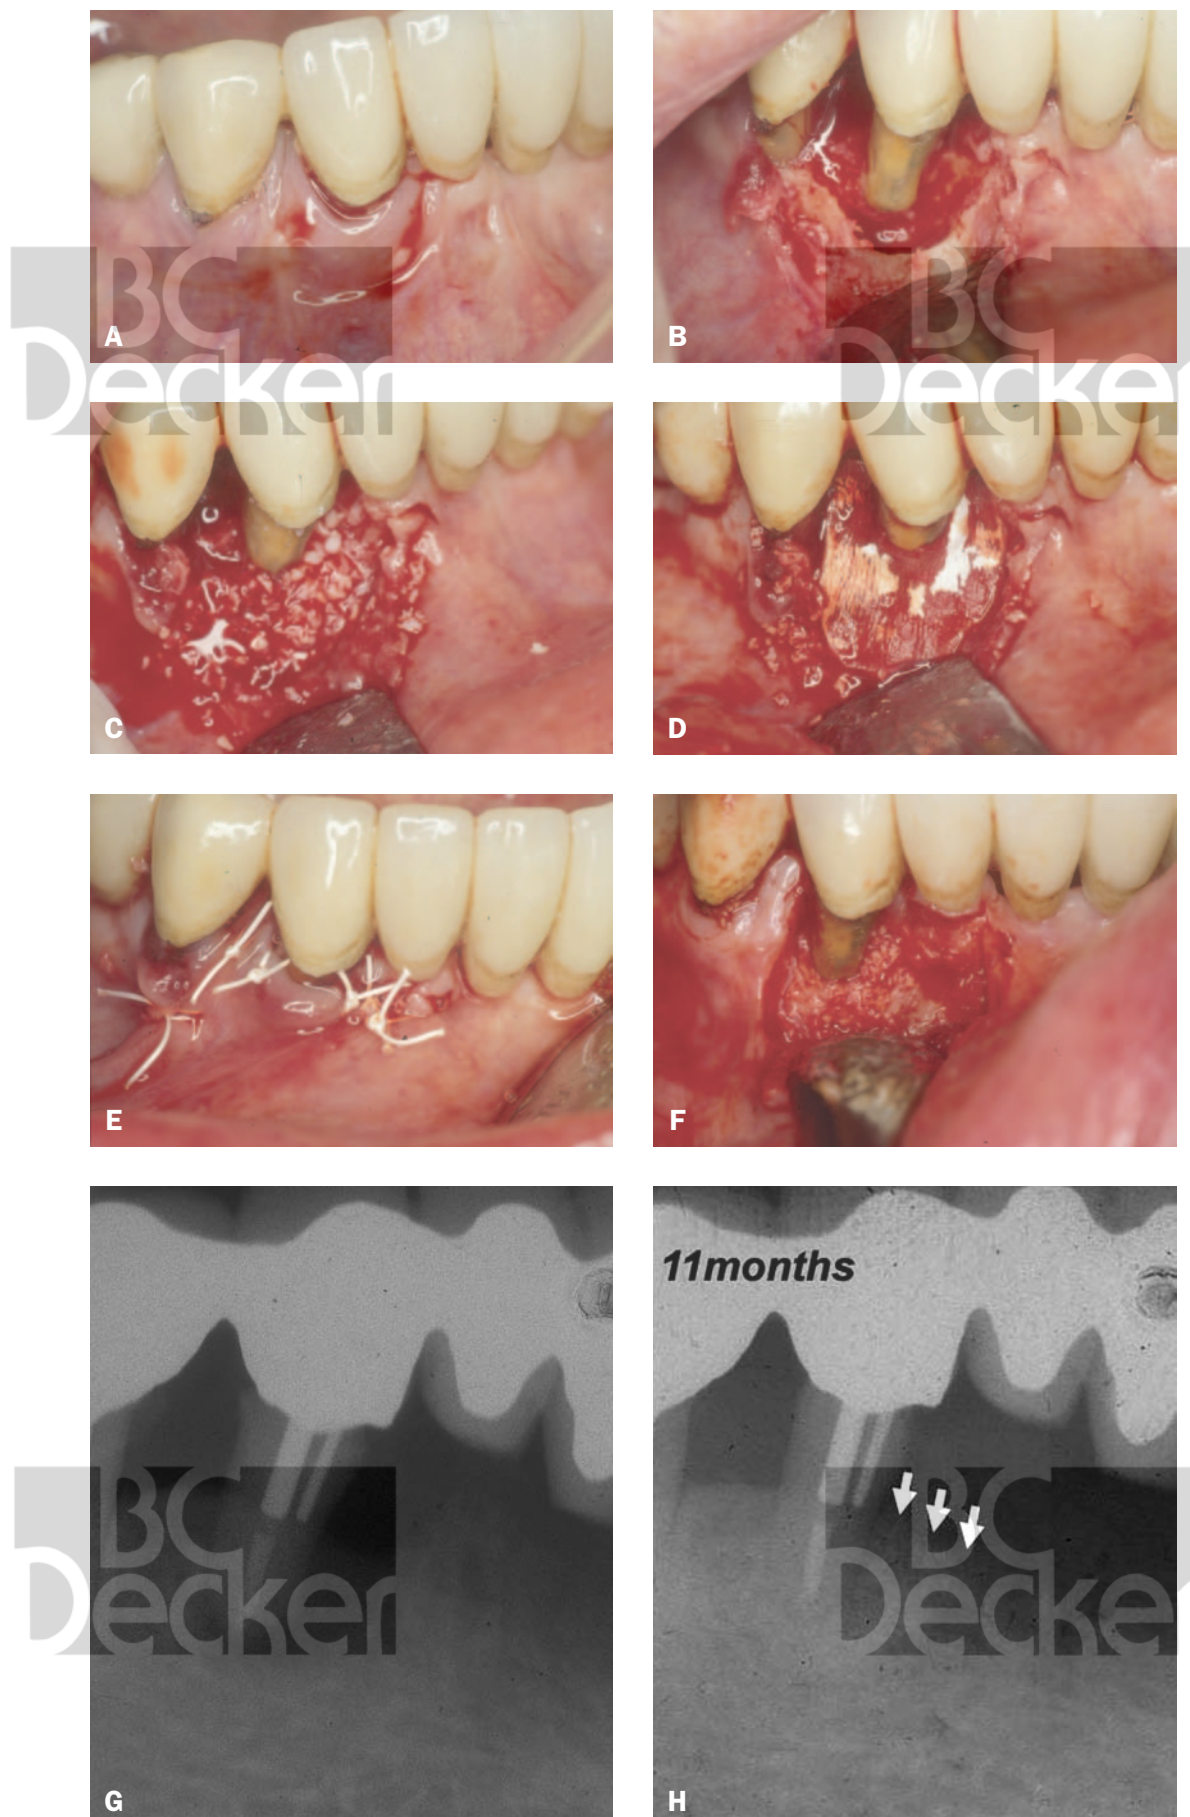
Guided tissue regeneration, Bio-Oss/BioGuide. *A*, Before treatment. *B*, Defect granulation. *C*, Bio-Oss positioned. *D*, BioGuide positioned. *E*, Flap replaced and sutured with Gore-Tex sutures. *F*, Reentry 11 months later. Complete defect resolution. *G* and *H*, Pre- and post-treatment radiographs showing complete regeneration.
